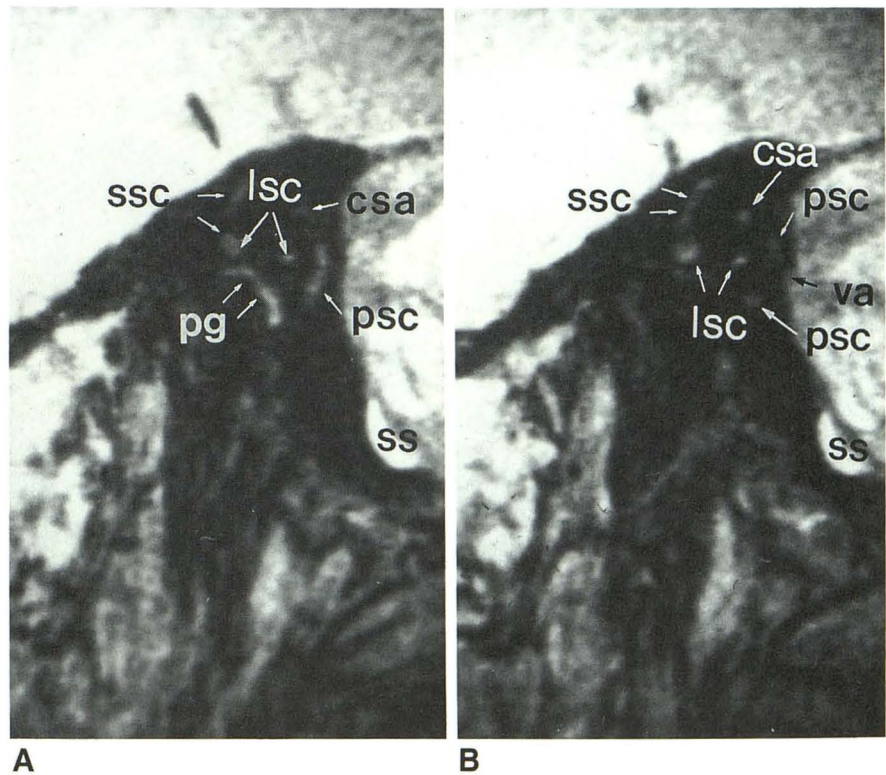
Sagittal 3DFT MR images. See key for abbreviations.
